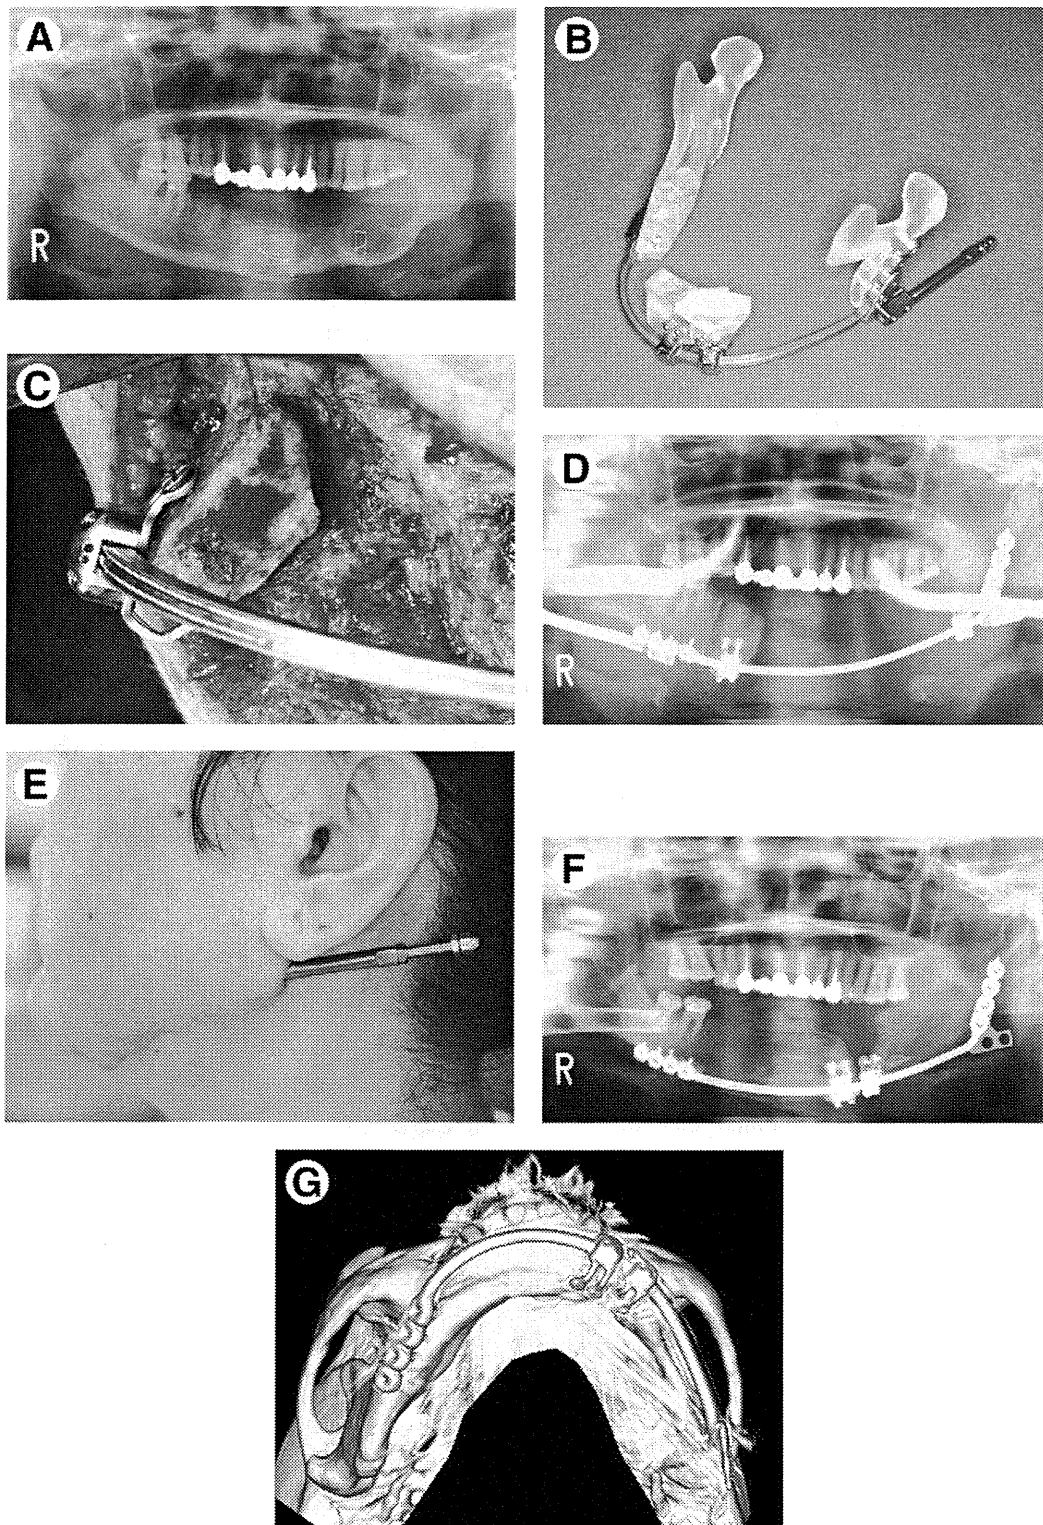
A, The mandible with a fourth recurrent ameloblastoma. Panoramic radiogram revealed radiolucent images in the mesial and distal borders of the sectioned mandible and the interpositioning iliac bone graft. B, A custom-made distraction device on the patient's stereolithographic model. Locking plates and screws enabled suprapariosteal fixation of the transport segments. C, The transport segment fixed with the locking plates and screws suprapariosteally. D, The transport segments before distraction. Immediately after surgery, panoramic radiogram showed the distraction device and 2 transport segments in their initial positions. E, The percutaneous traction mechanism of the distraction device. Activation of the mechanism moved the transport segment through a traction wire. F, Fourteen months after distraction, the panoramic radiogram showed newly formed bone with progressing density in the distraction gaps. G, Fourteen months after distraction, CT showed that newly formed bones in the distraction gaps, and the transport segments composed a multangular form resembling the mandibular curvature.
